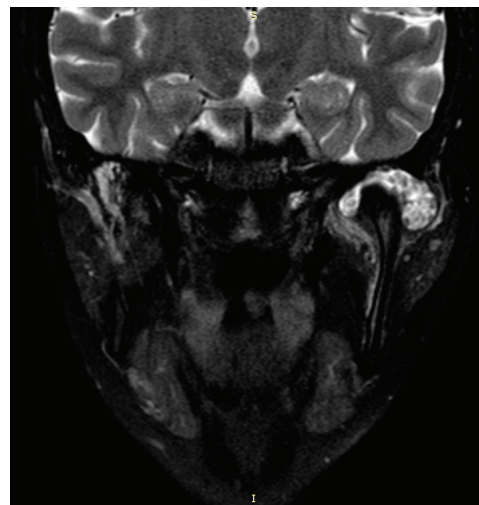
MRI - frontal scan through left TMJ, cartilaginous bodies visible in the articular cavity
